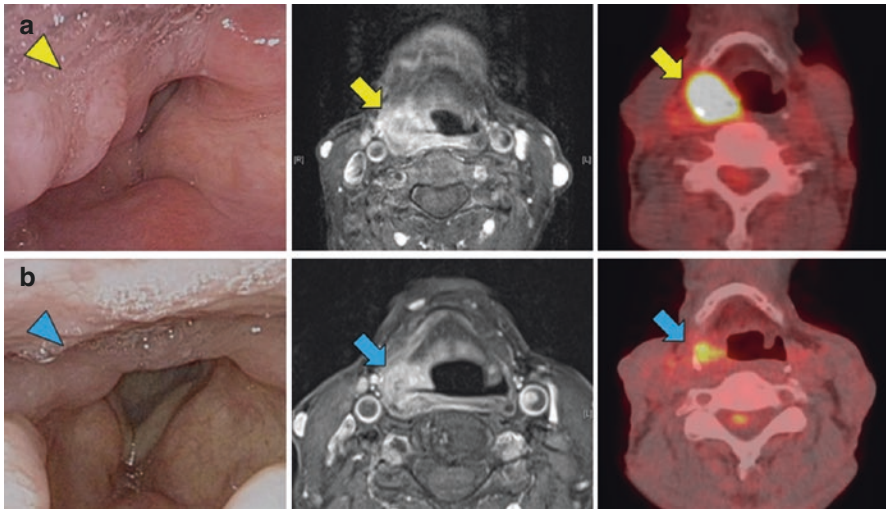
Prediction of the response to neoadjuvant chemotherapy (NAC) for head and neck cancer using FDG PET/CT. A 75-year-old man with a right pyriform sinus squamous cell carcinoma (UICC eighth edition: cT4aN2aM0). The patient underwent fiberoptic, magnetic resonance imaging (MRI), and FDG PET/CT before (a) and 3 weeks after (b) one cycle of NAC (the platinum complex nedaplatin and the oral fluoropyrimidine derivative S-1). The arrowheads indicate a hypopharyngeal tumor observed with the fiberoptic. The arrows indicate the tumor on the contrast-enhanced MR and PET/CT images. On MRI, the maximal diameter after NAC was almost comparable with that before NAC, whereas the maximum standardized uptake value in PET/CT showed a 79% decrease (from 21.7 to 4.5), indicating good response to NAC. The patient subsequently underwent definitive chemoradiotherapy and exhibited a complete response
